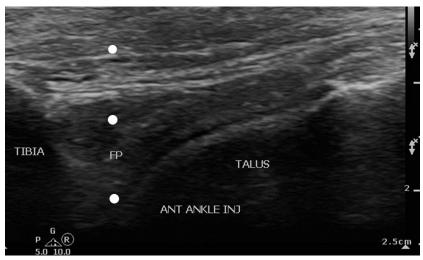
Sonographically guided injection of ankle joint, long axis to joint, needle path out of plane with transducer. Dots represent path of needle. Each dot signifies a pass of the needle tip below the ultrasound beam. The needle is directed along a steeper trajectory with each pass until the tip is visualized deep to the FP. Left, proximal; right, distal.
